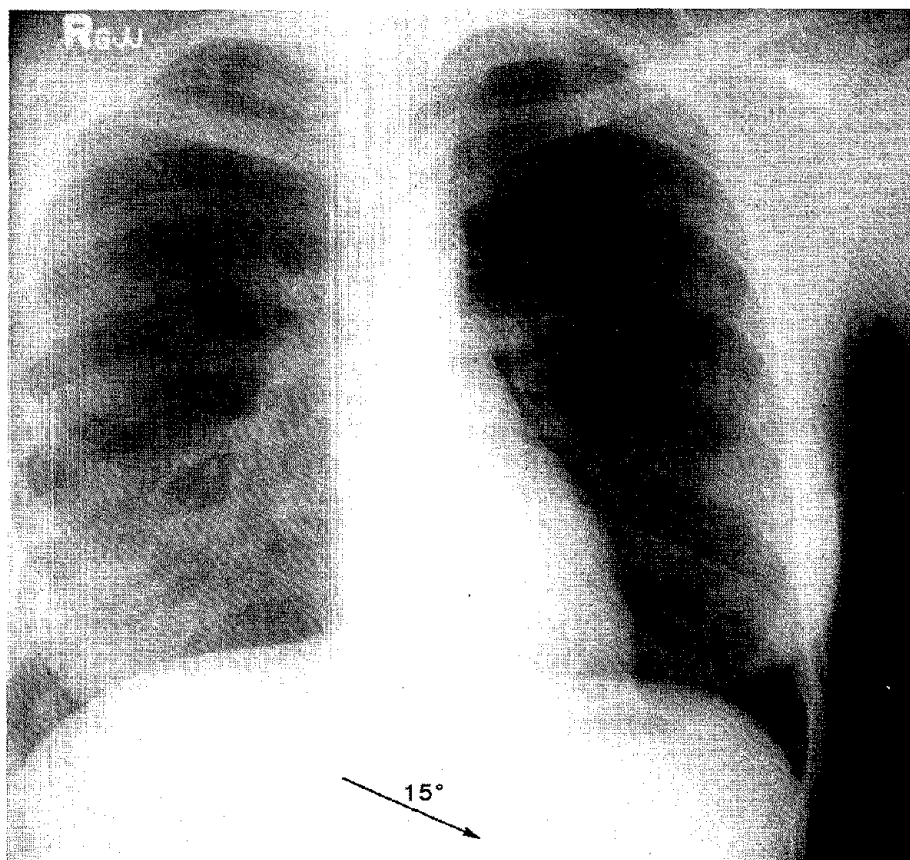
The x-ray tube is misaligned in relation to the surface of the grid and the cassette. Note the unwanted grid line artifact shadows. There is loss of density and detail of the images. The higher the grid ratio the more critical the required focusing, centering, and leveling.
